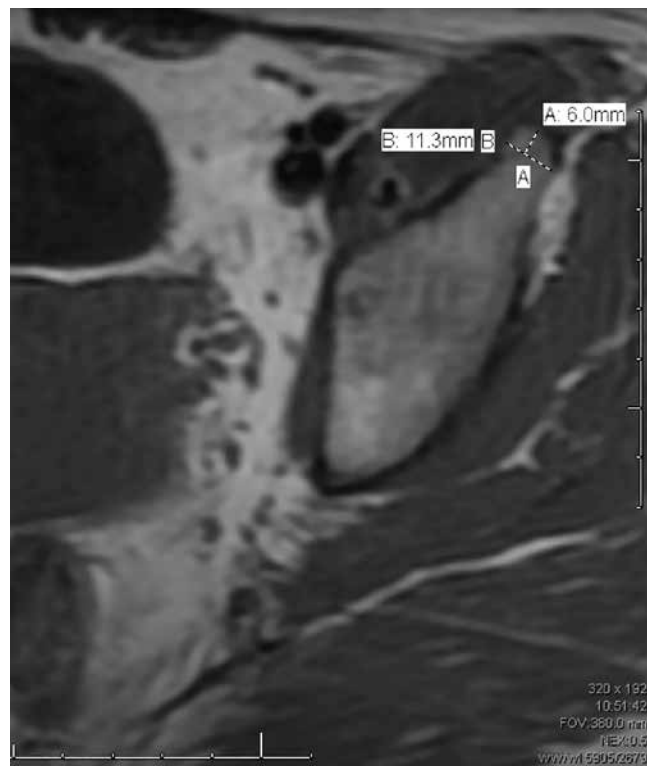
Measurement of the width (11.3 mm) of the anterior inferior iliac spine using axial view MRI.
